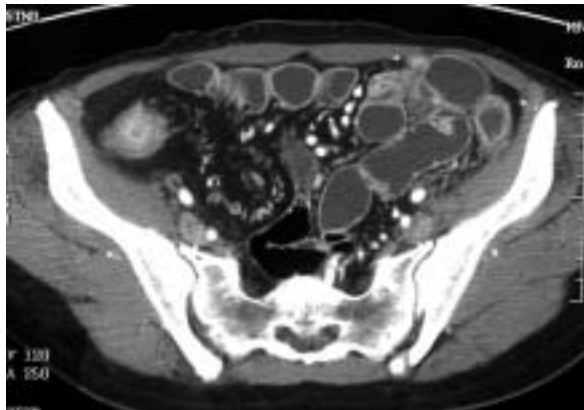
Multidetector CT enteroclysis showing thickening of terminal ileum, “target sign” and “perienteric stranding”.
